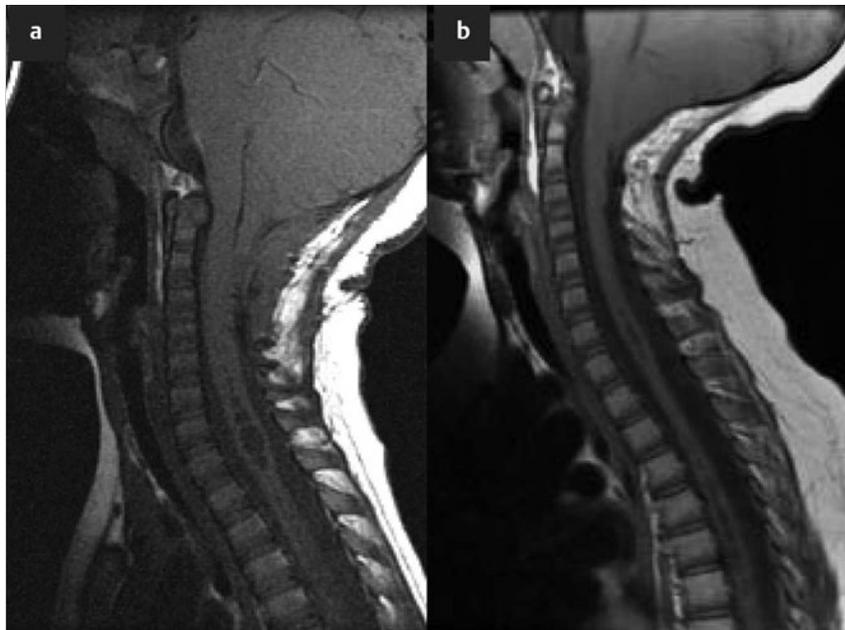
(a) Sagittal magnetic resonance image of a patient with spina bifida showing a Chiari 2 malformation and syringomyelia. (b) The syrinx resolved after ventriculoperitoneal shunt revision.
